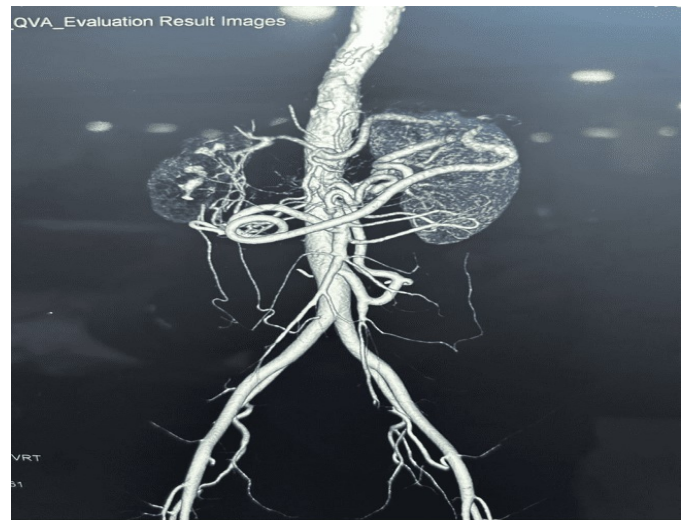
CT abdomen show stenosis of right renal artery
